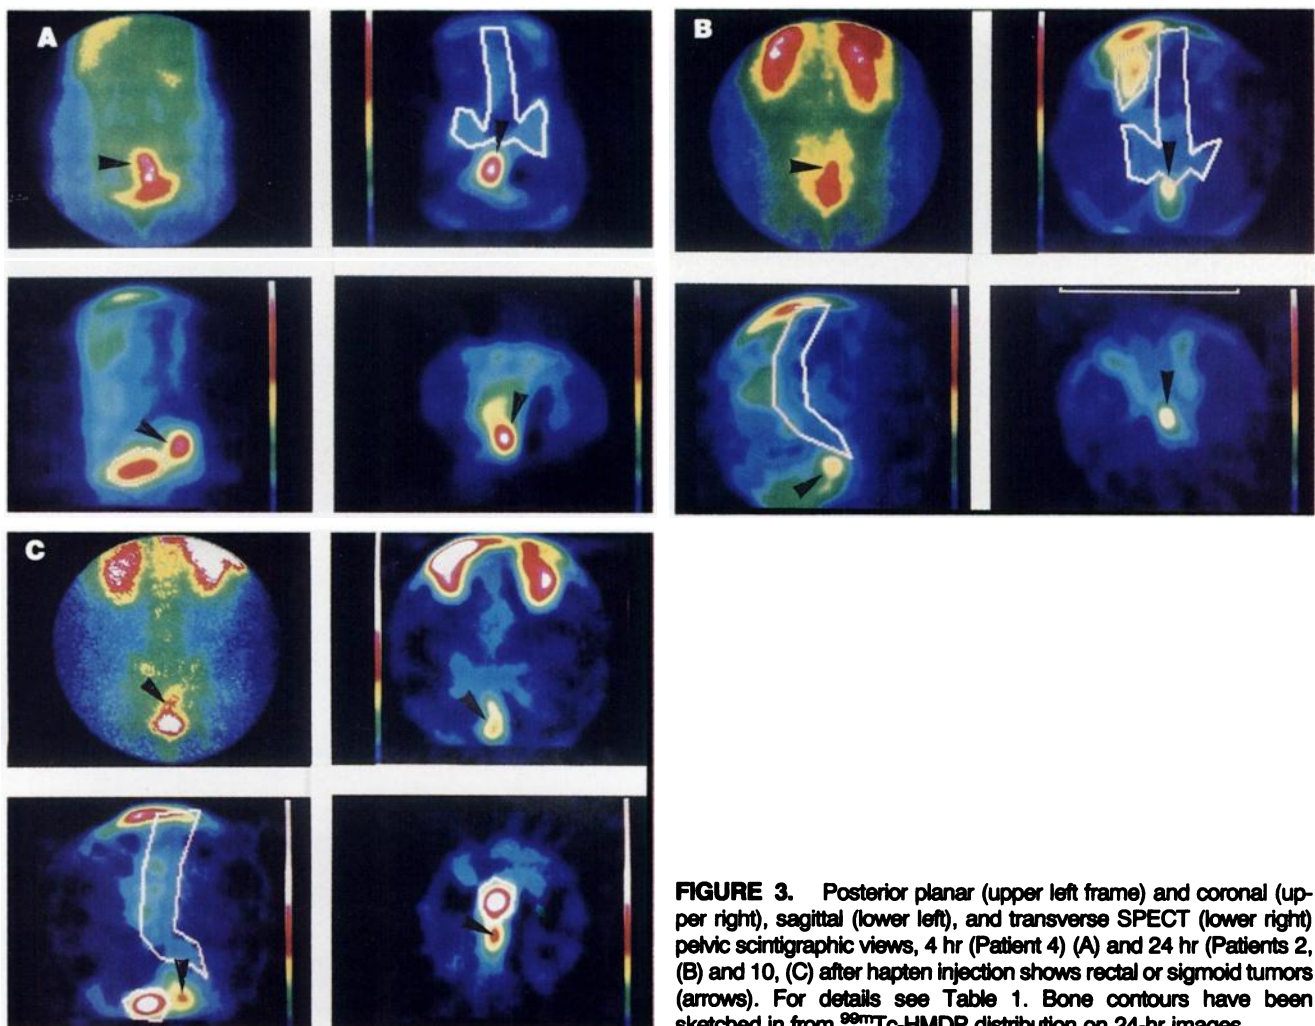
Posterior planar (upper left frame) and coronal (upper right), sagittal (lower left), and transverse SPECT (lower right) pelvic scintigraphic views, 4 hr (Patient 4) (A) and 24 hr (Patients 2, (B) and 10, (C) after hapten injection shows rectal or sigmoid tumors (arrows). For details see Table 1. Bone contours have been sketched in from ^{99m}Tc -HMDP distribution on 24-hr images.
